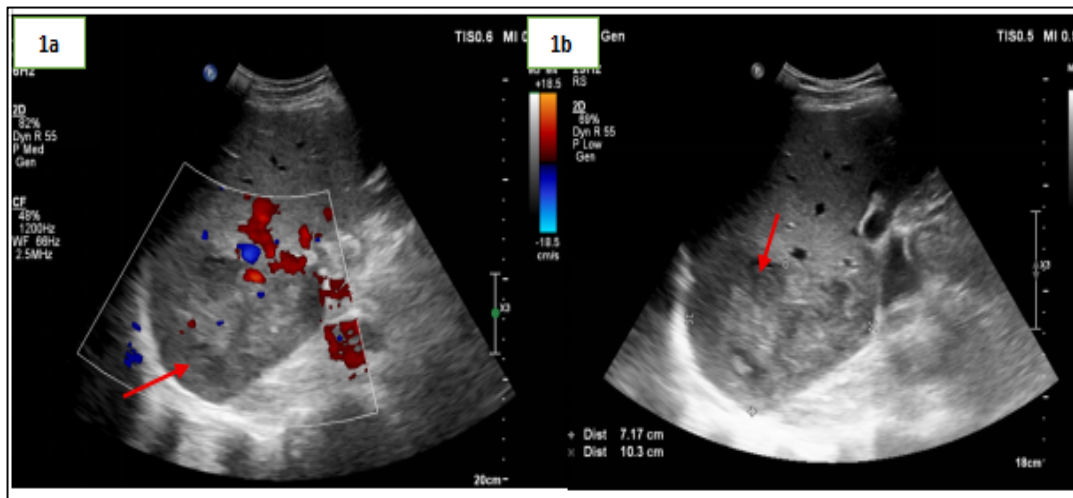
Ultrasound abdomen of a 45-year-old male patient with known hepatitis B infection showing a well-defined lobulated hypoechoic space-occupying lesion in segment VII and VI of the right lobe of the liver (red arrows), measuring 10.3×7.1 cm with internal vascularity. The lesion extends up to the liver capsule, suggestive of a neoplastic etiology
